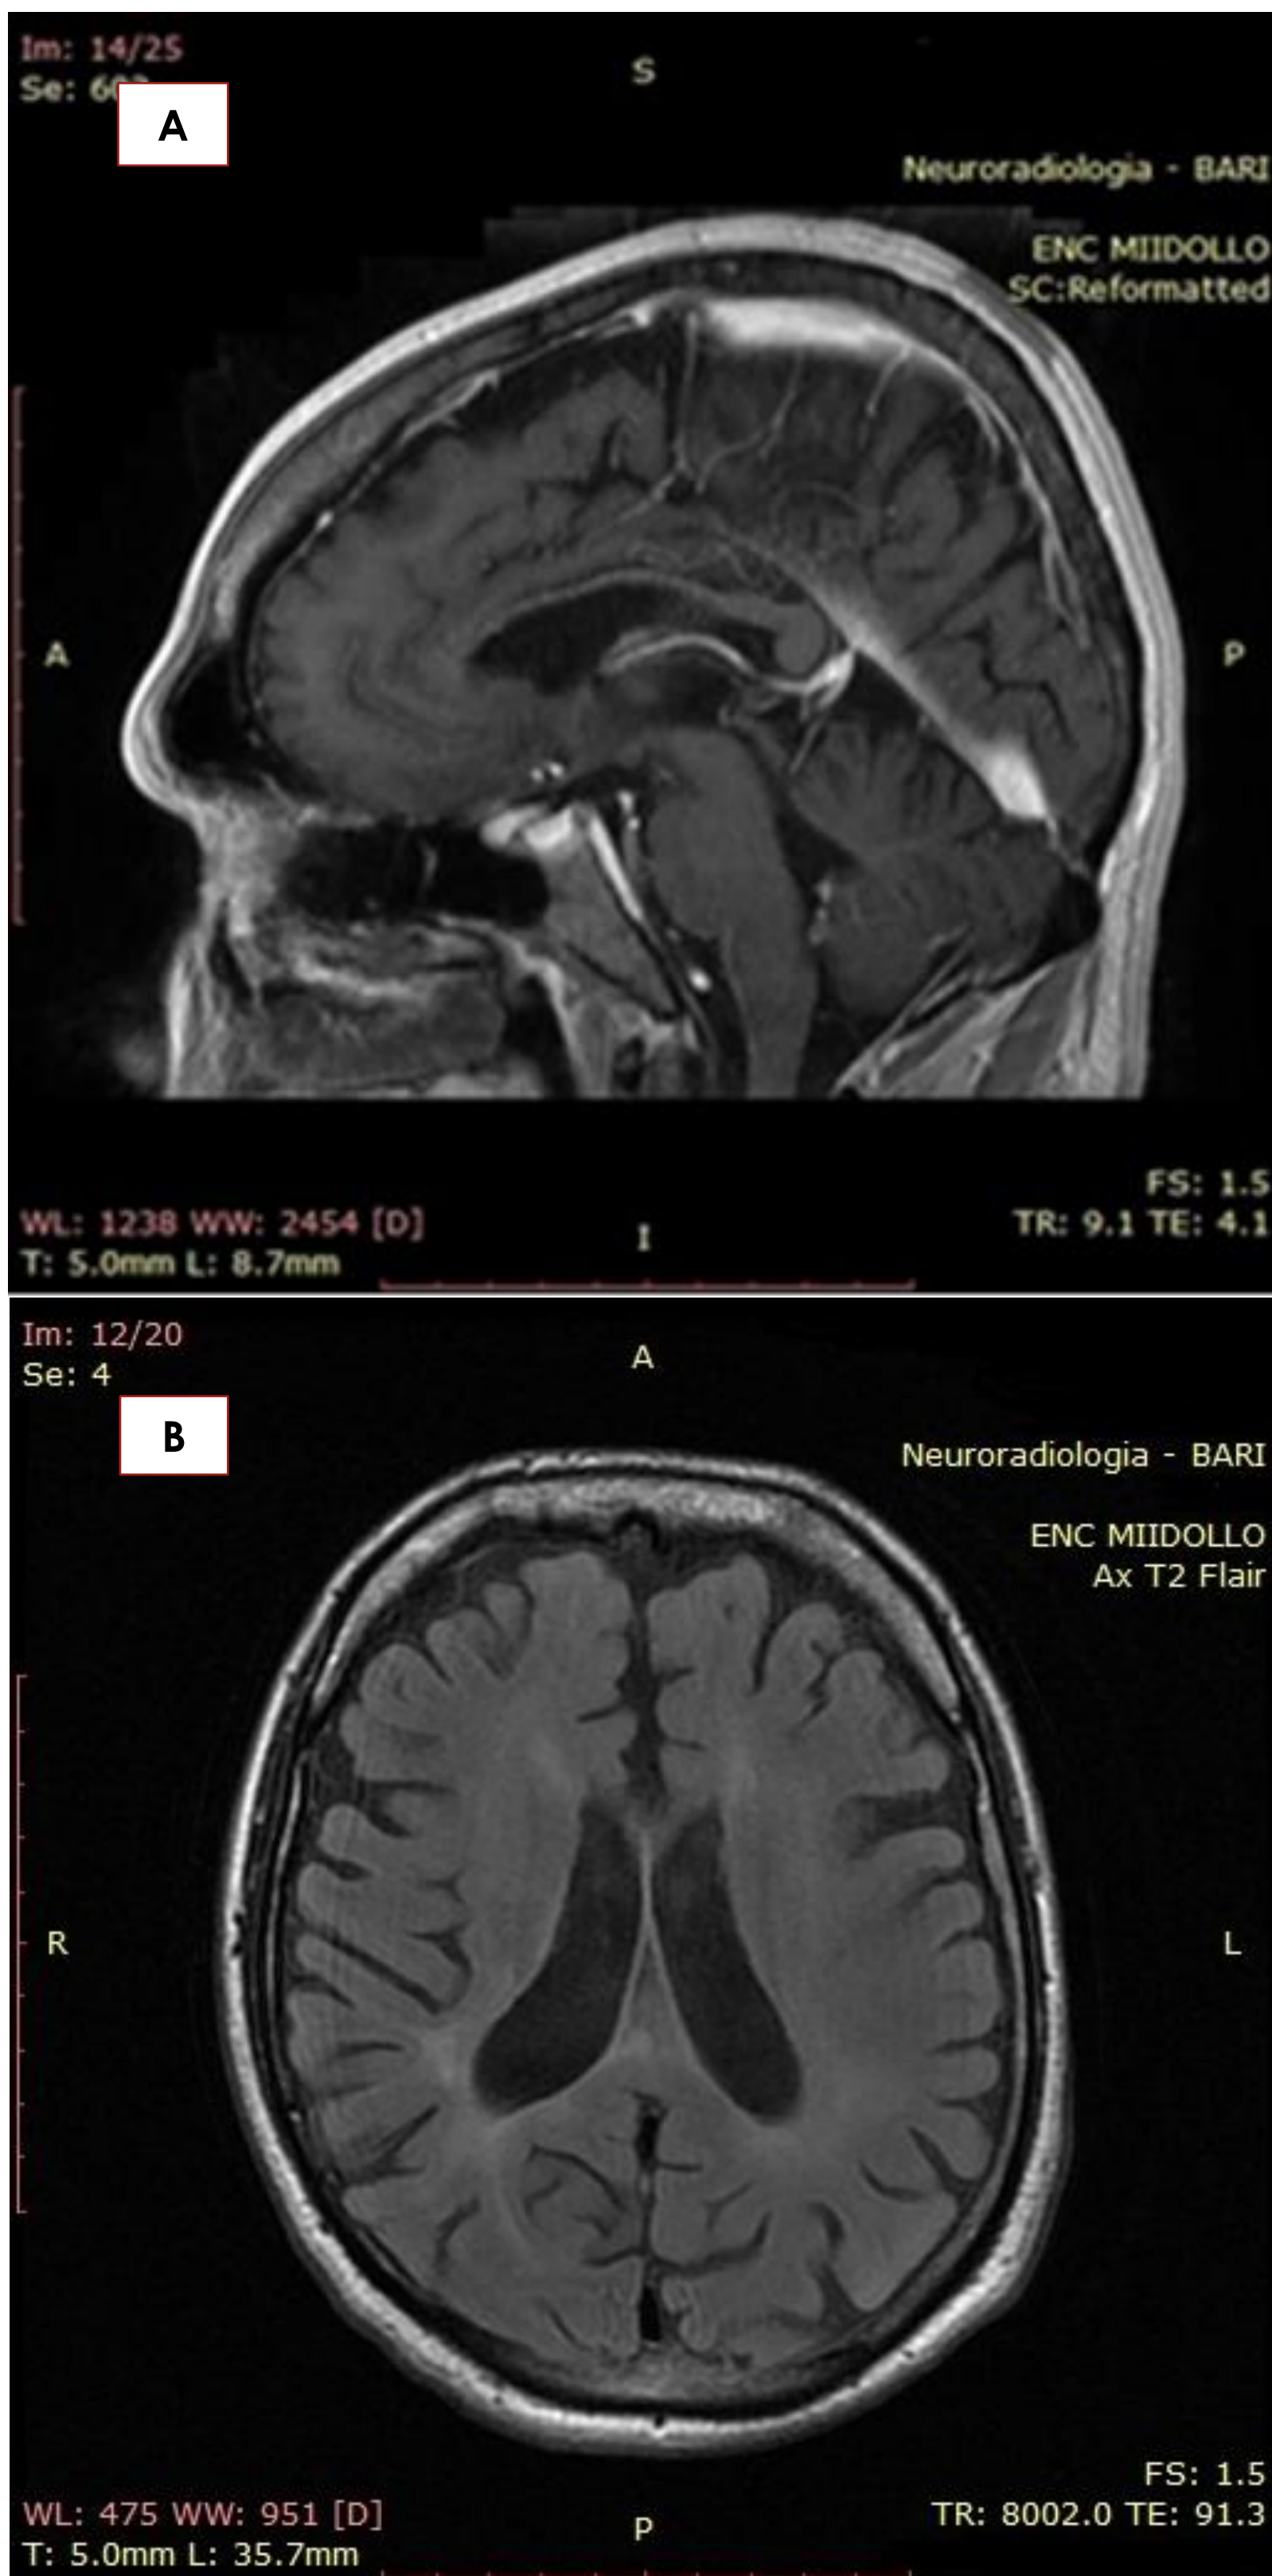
(A) T1 MRI brain sagittal section showed considerable thinning of the anterior part and the body of corpus callosum: (B) Flair axial section showed periventricular and subcortical white matter hyperintensity
